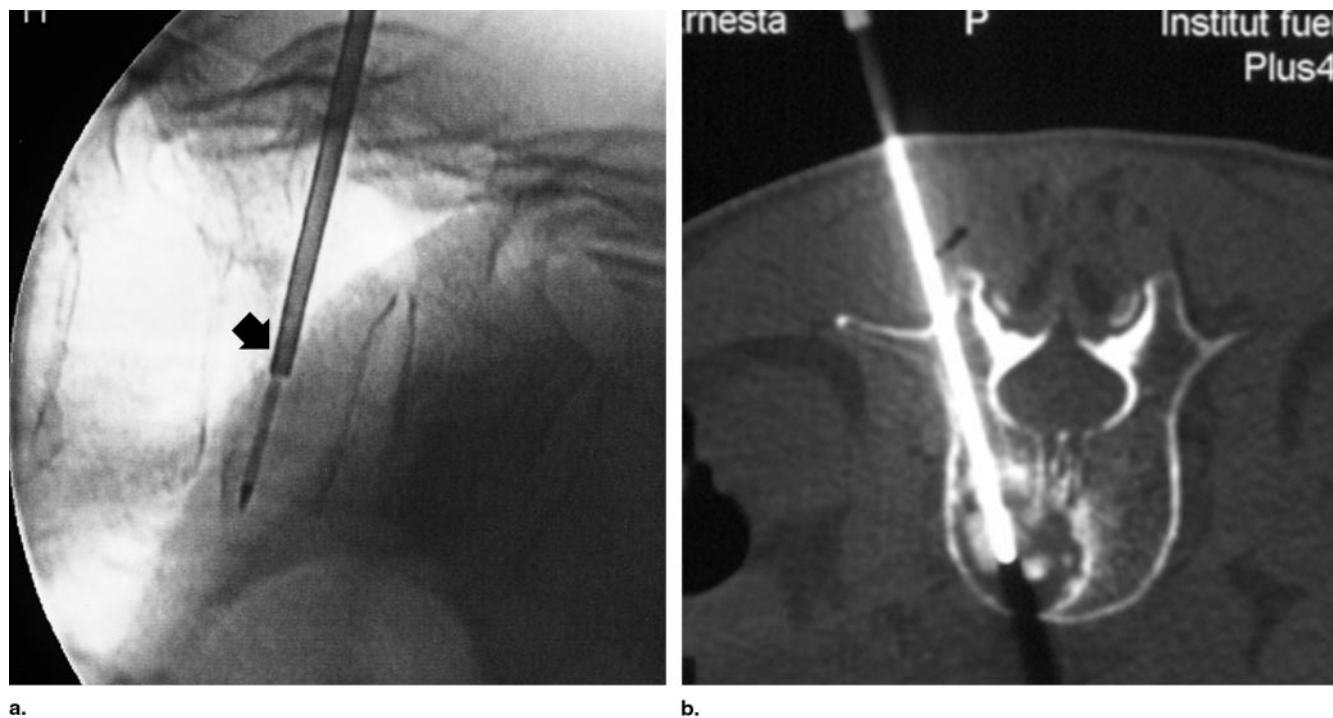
Thermal ablation of a vertebral tumor performed with combined CT and fluoroscopic guidance. (a) Lateral fluoroscopic view of the bone biopsy cannula (arrow) and inserted RF electrode. (b) Same segment on a CT scan. Lateral real-time fluoroscopic view enables three-dimensional orientation during the procedure.
